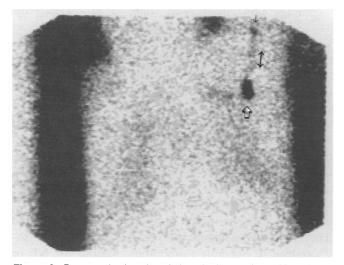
Preoperative lymphoscintigraphy in a patient with an intermediate-thickness melanoma on the left arm. The left arm is held above the head to maximize distance between the primary site and the regional basin. The body outline is masked behind the lymphoscintigraphy. Injection around the primary site and imaging at 10 minutes shows an afferent lymphatic (double-headed arrow) leading to an intransit node (outside the classic regional basin, small solid arrow). This in-transit node is located in the upper medial arm. In addition, a sentinel lymph node (SLN) is identified in the left axilla (open arrow). Both nodes were harvested and both contained metastatic melanoma. After a complete node dissection, the SLN was the only site of disease in the axilla.
